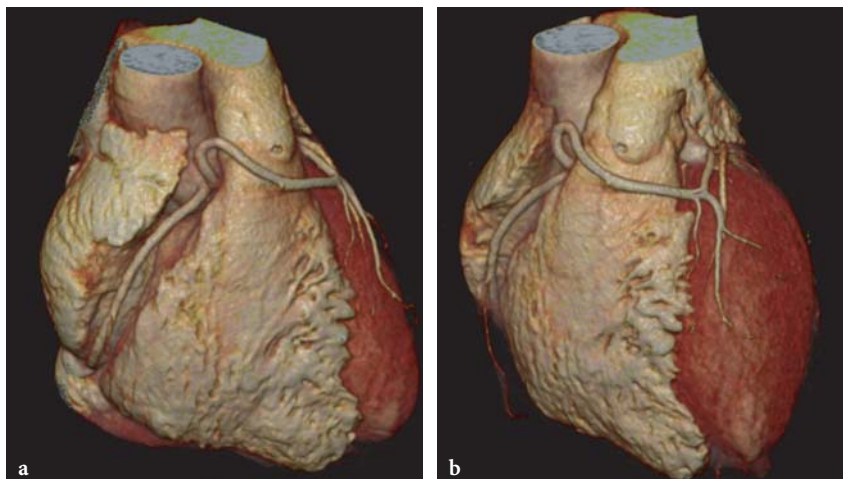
16-slice CT examination demonstrating the origin of the LMA from a common ostium with the RCA at the right sinus of Valsalva. The artery courses ventral to the pulmonary artery to the left side. Volume-rendering reconstructions in ventral view (a) and along the course of the LMA ventral to the pulmonary trunk before the artery branches into the LAD and CX (b). Note the ectopic origin of the first diagonal branch out of the LMA
